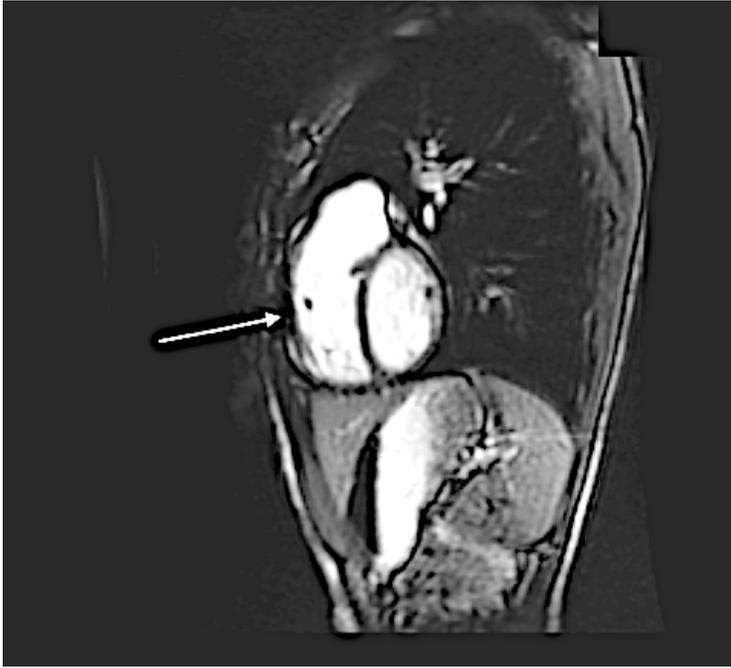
Sagittal MRI demonstrating right ventricular enlargement (white arrow) with mild compression of the left ventricle.
